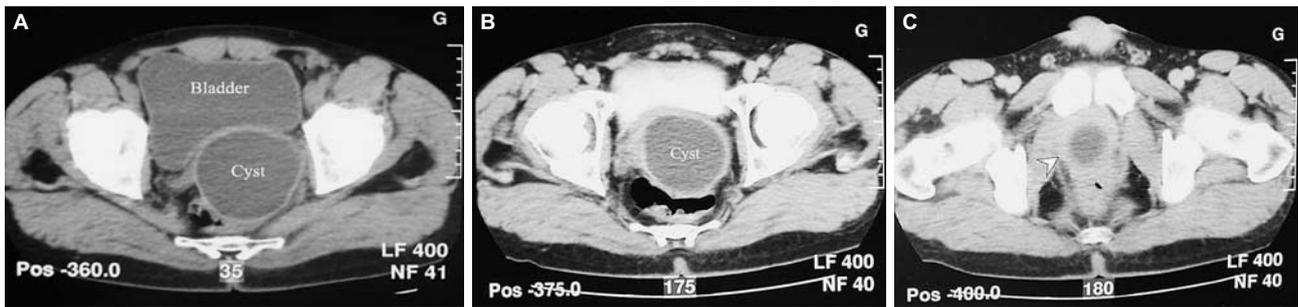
A. Computed tomography scan reveals a pelvic cystic mass displacing the bladder anteriorly. B & C. Computed tomography scan shows a hyperdense rim around the mass after administration of intravenous contrast medium.
